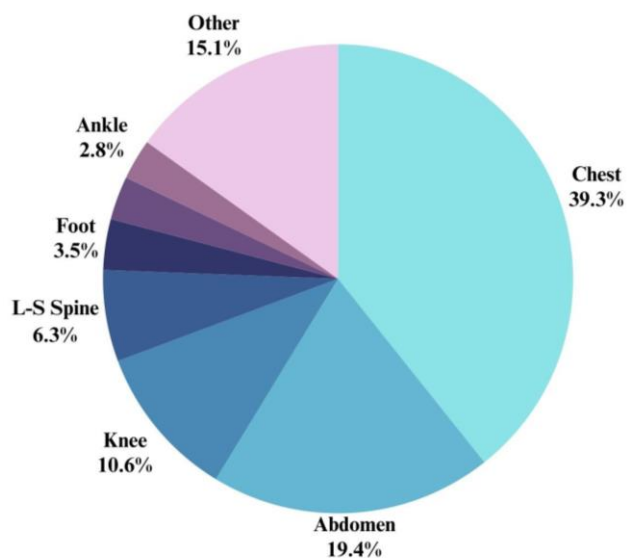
The proportion of the number of radiographic images for each type of examination.
